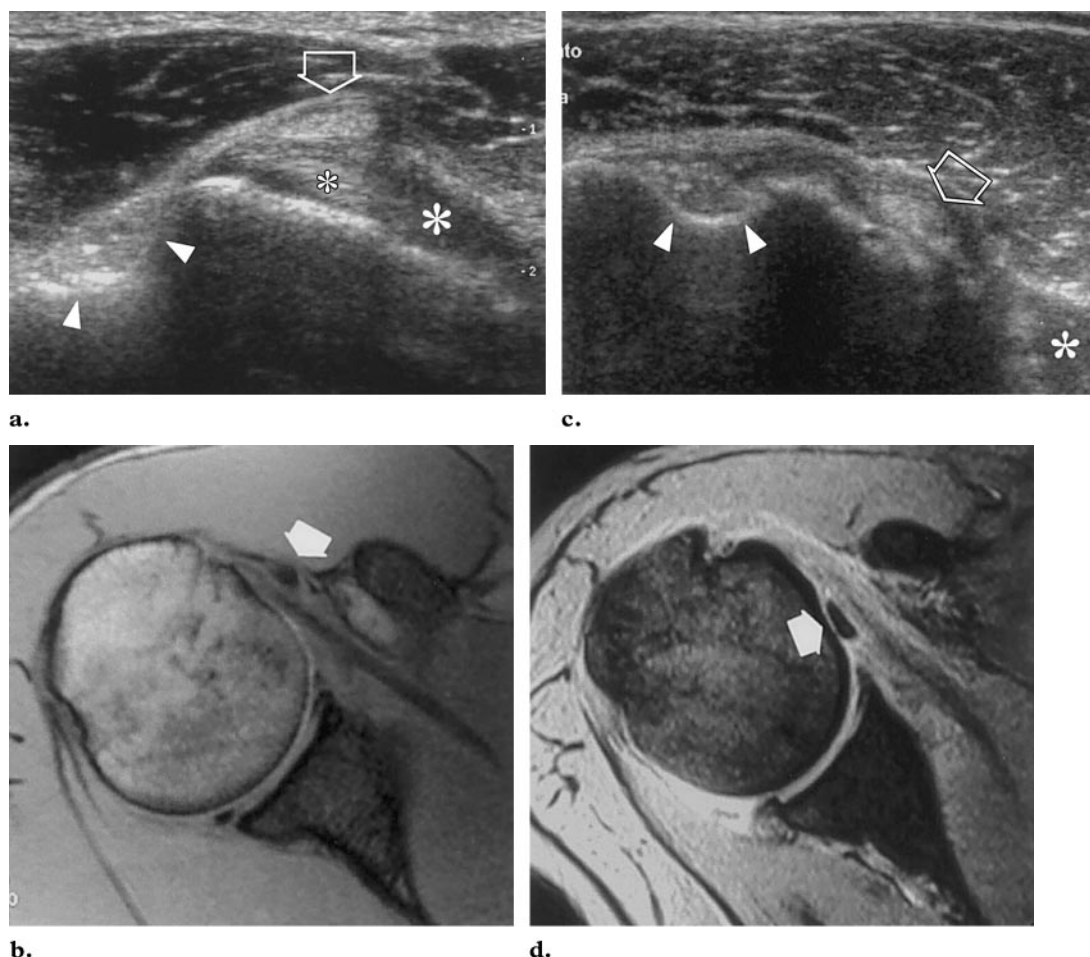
Biceps tendon dislocation. (a, b) Intact subscapularis tendon in a 27-year-old man with biceps tendon instability. Transverse 12–5-MHz US image (a) and corresponding gradient-recalled-echo (GRE) MR image (repetition time msec/echo time msec/flip angle = 400/12/90°) (b) demonstrate the biceps tendon (arrow) displaced superficial to the intact subscapularis tendon (* in a). Note that the intertubercular sulcus (arrowheads in a) is obtuse. (c, d) Full-thickness tear of the subscapularis tendon in a 58-year-old man with impingement syndrome. On a transverse 12–5-MHz US image (c) and corresponding GRE MR image (550/15/25°) (d), the torn subscapularis tendon (* in c) is retracted from its normal attachment point on the lesser tuberosity, and the biceps tendon (arrow) is dislocated medially out of the groove (arrowheads in c).
